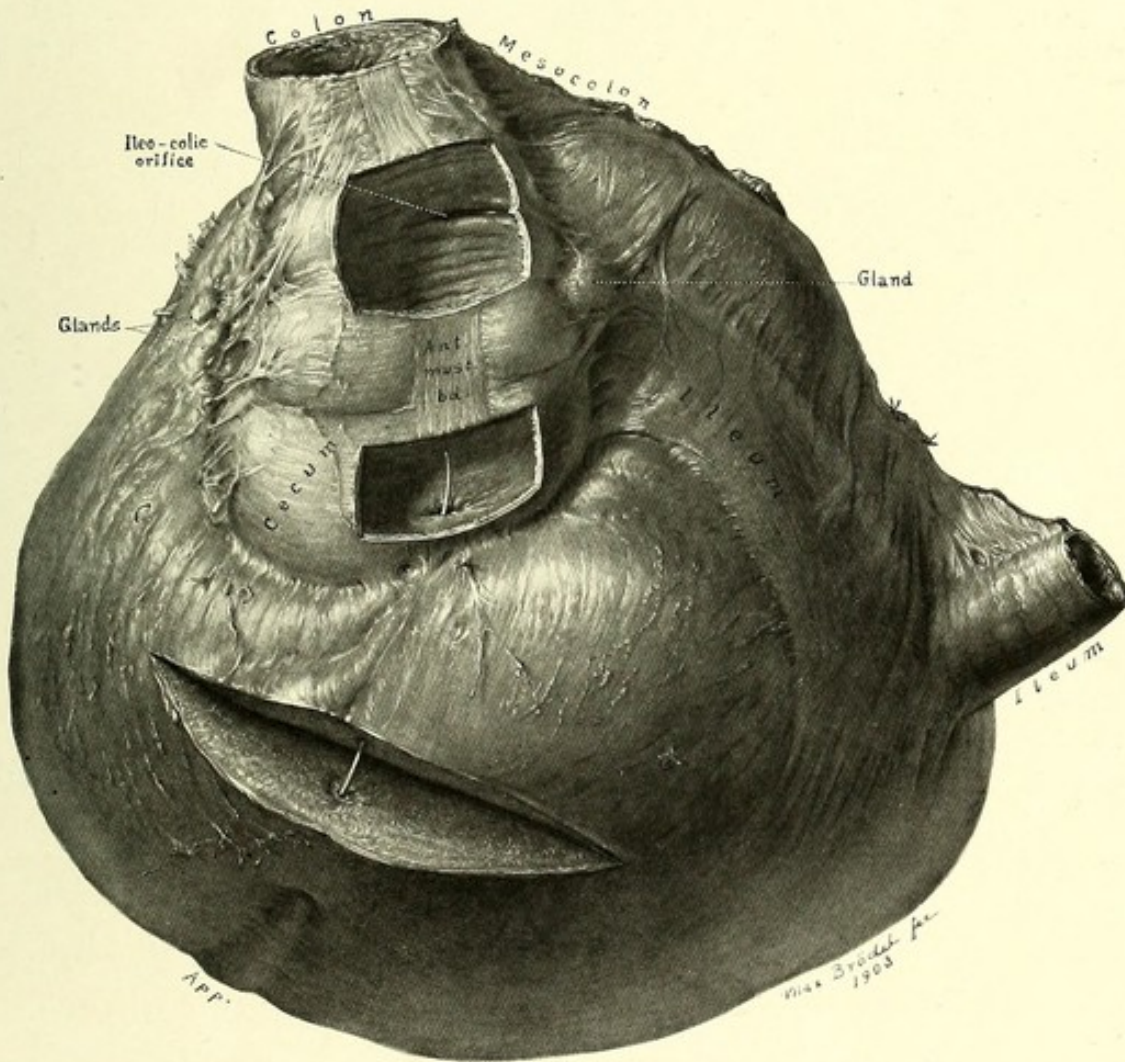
H. A. KELLY. FIBROMA OF THE APPENDIX AND APPENDICO-CECAL ANGLE. ANTERIOR ASPECT OF TUMOR. (M. P., age thirty-three. Jan. 22, 1900.)
